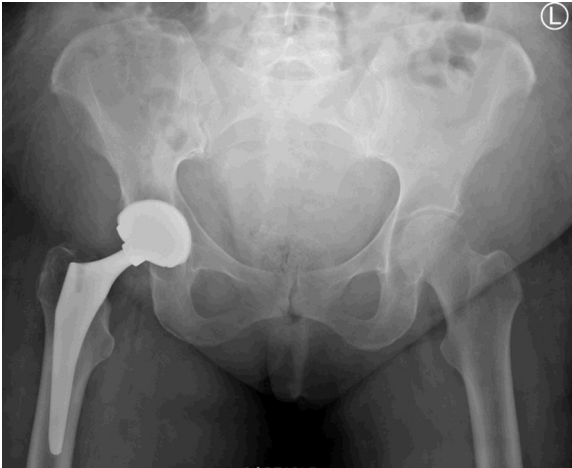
Anteroposterior (AP) radiograph of case 2 at presentation with dual mobility right THA without radiographic evidence of failure.
